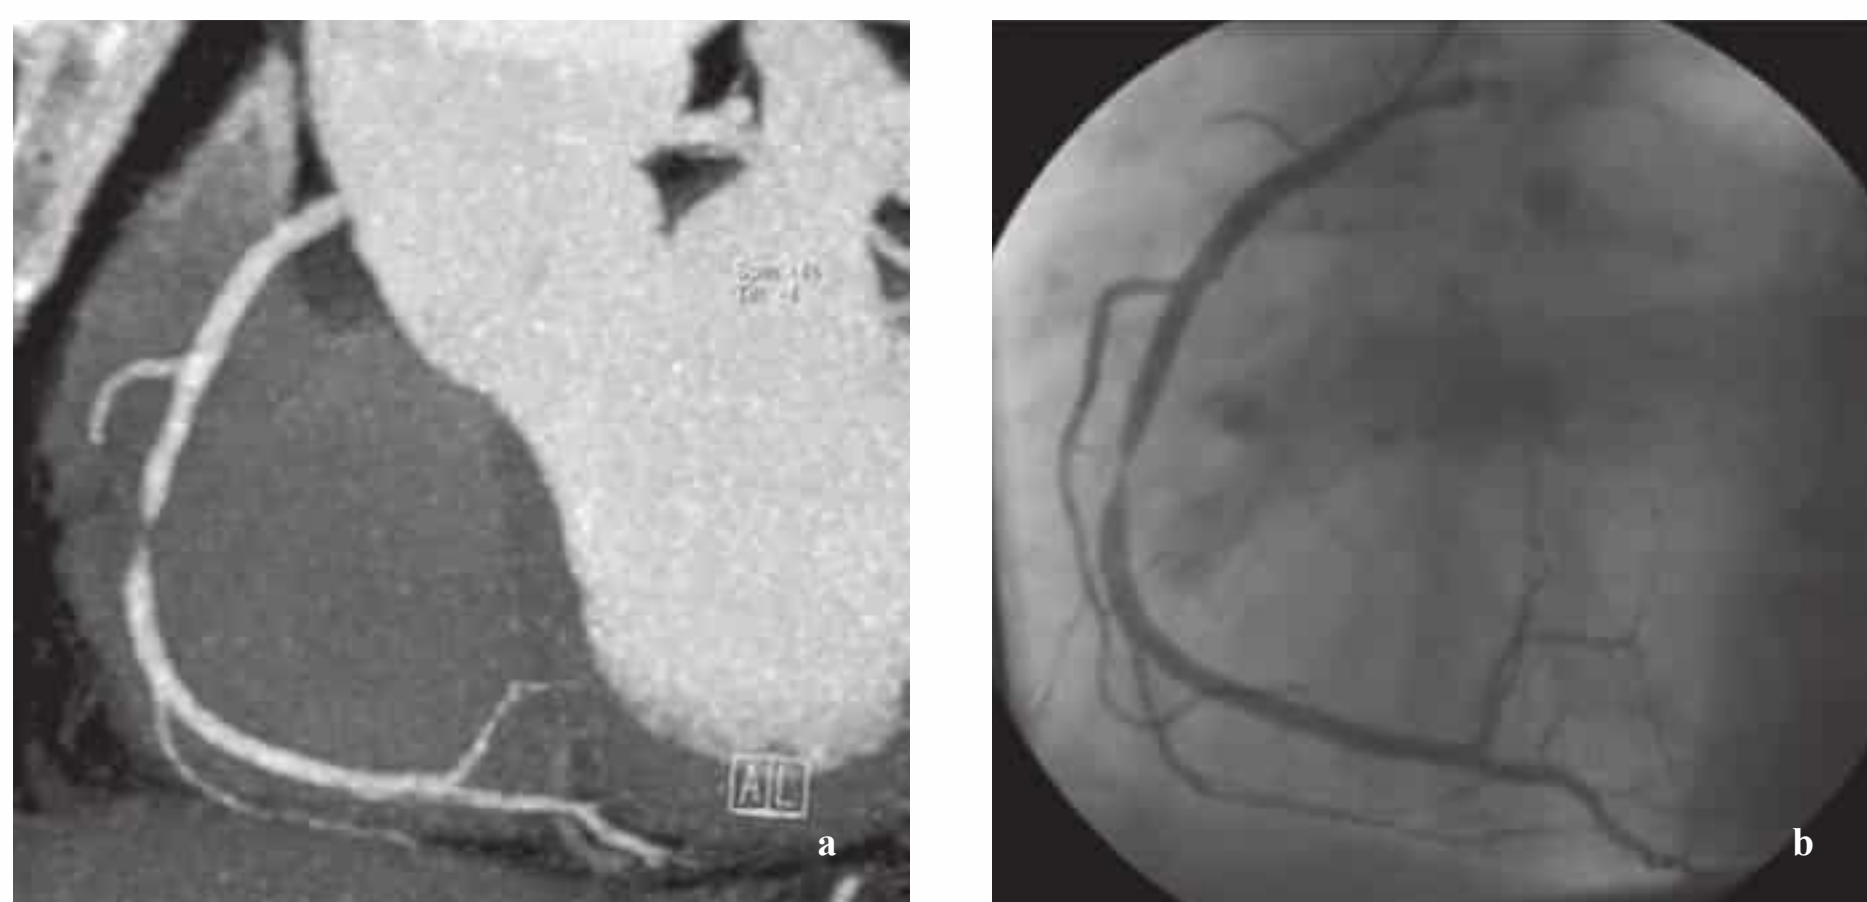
a, b High-grade stenosis in the midportion of the RCA, diagnosed by CT coronary angiography (a). The finding was confirmed by subsequent invasive coronary angiography (b).
